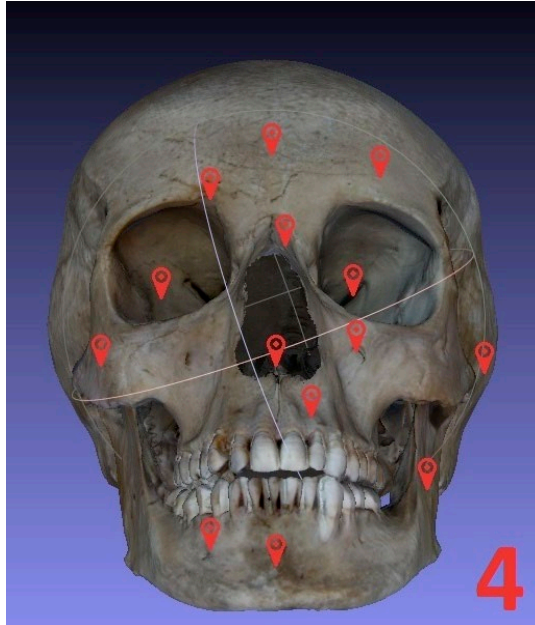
Scale superimposition of the 3D reconstruction from CT images, of the three-dimensional model from the non-contact surface scanning and of the high definition photos of the skull of preceding figures.
